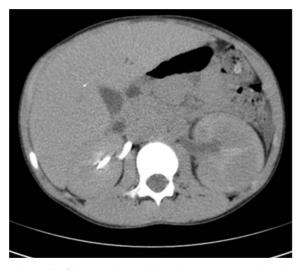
CT scan (case 2): left nephromegalia with hypodense areas
